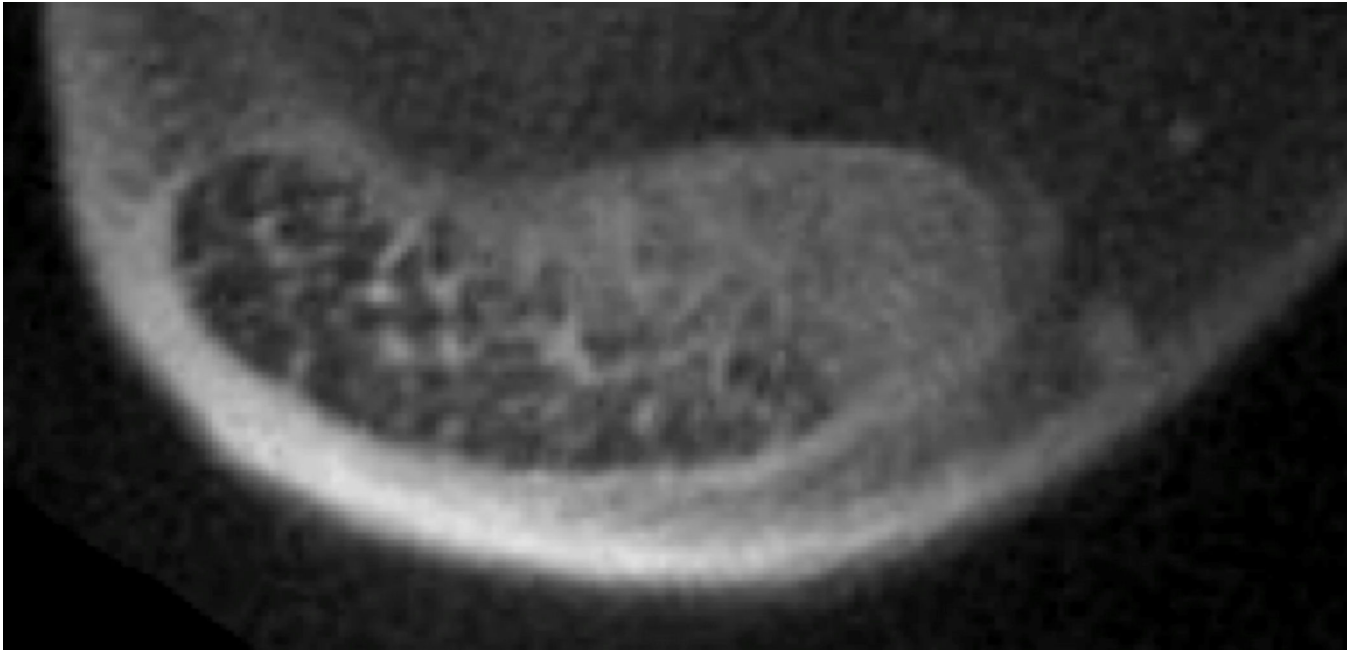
Axial UTE MR image of Achilles tensile tendon demonstrates differential microstructure of the tendon with geographic effacement of the normal fascicular appearance within the tendon representing intrasubstance degeneration.
